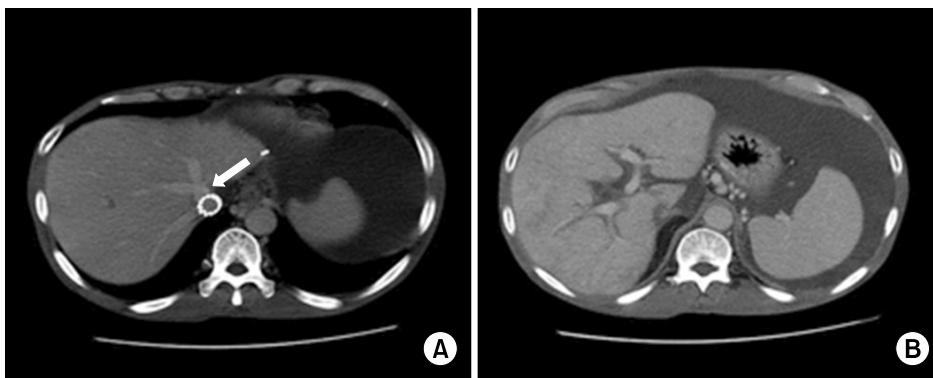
This contrast-enhanced abdominal computed tomography (CT) scan shows a collapsed inferior vena cava (IVC) chamber on the donor side, a large amount of ascites fluid and liver graft congestion. (A) In comparison with the previous CT scan, the donor side IVC chamber had collapsed from extrinsic compression of the Palmaz stent (arrow). (B) A mottled pattern of contrast enhancement was observed in the portal venous phase.
